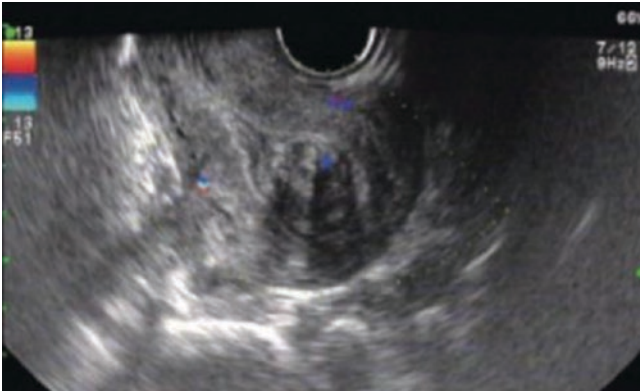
Submucous myoma. A 48-year-old patient with menorrhagia for 2 years. Sonogram shows a solid mass with a diameter of nearly 2.5 cm in the uterine cavity. Submucous myoma is confirmed after an operation
